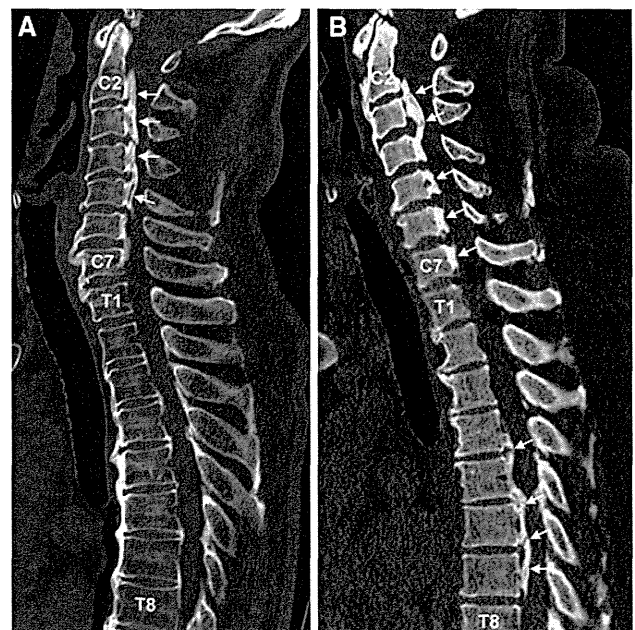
Representative, mid-sagittal reconstruction images of 3-dimensional computed tomography (CT) for type C-OPLL (a type of OPLL limited to the cervical spine) and type TL-OPLL (a type of OPLL extended to the thoracic and/or lumbar spine) patients. a A 66-year-old male patient where OPLL is limited to the cervical spine (type C-OPLL). b A 54-year-old female patient where OPLL is extended to the thoracic spine (type TL-OPLL). Arrows indicate OPLL. C2 2nd cervical vertebra, C7 7th cervical vertebra, T1 1st thoracic vertebra, T8 8th thoracic vertebra
